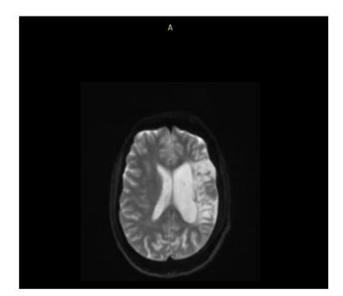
MRI Brain showing left cerebral hemiatrophy with exvacuo dilatation of ipsilateral lateral ventricle on T2 FLAIR (Left) and T2 (Right)
